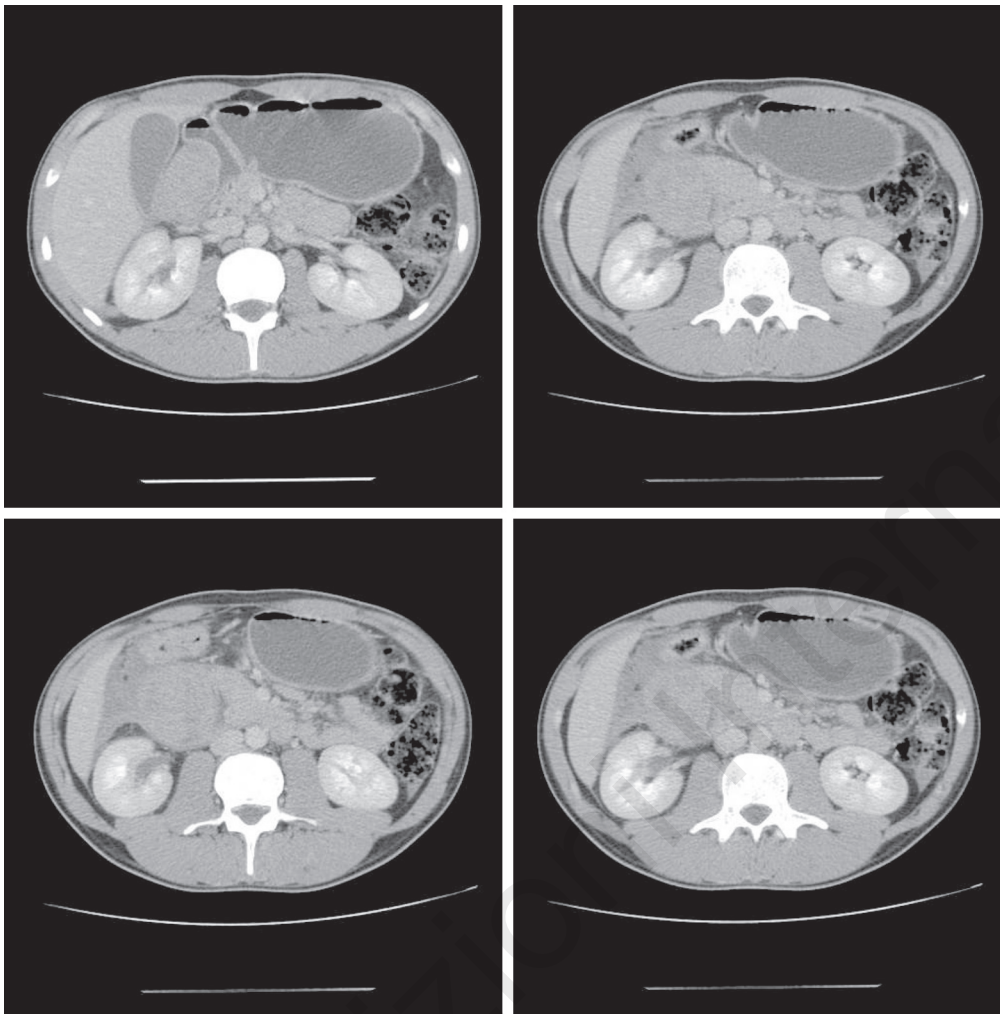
Abdominal CT scan reveals hematoma of the duodenum wall.
